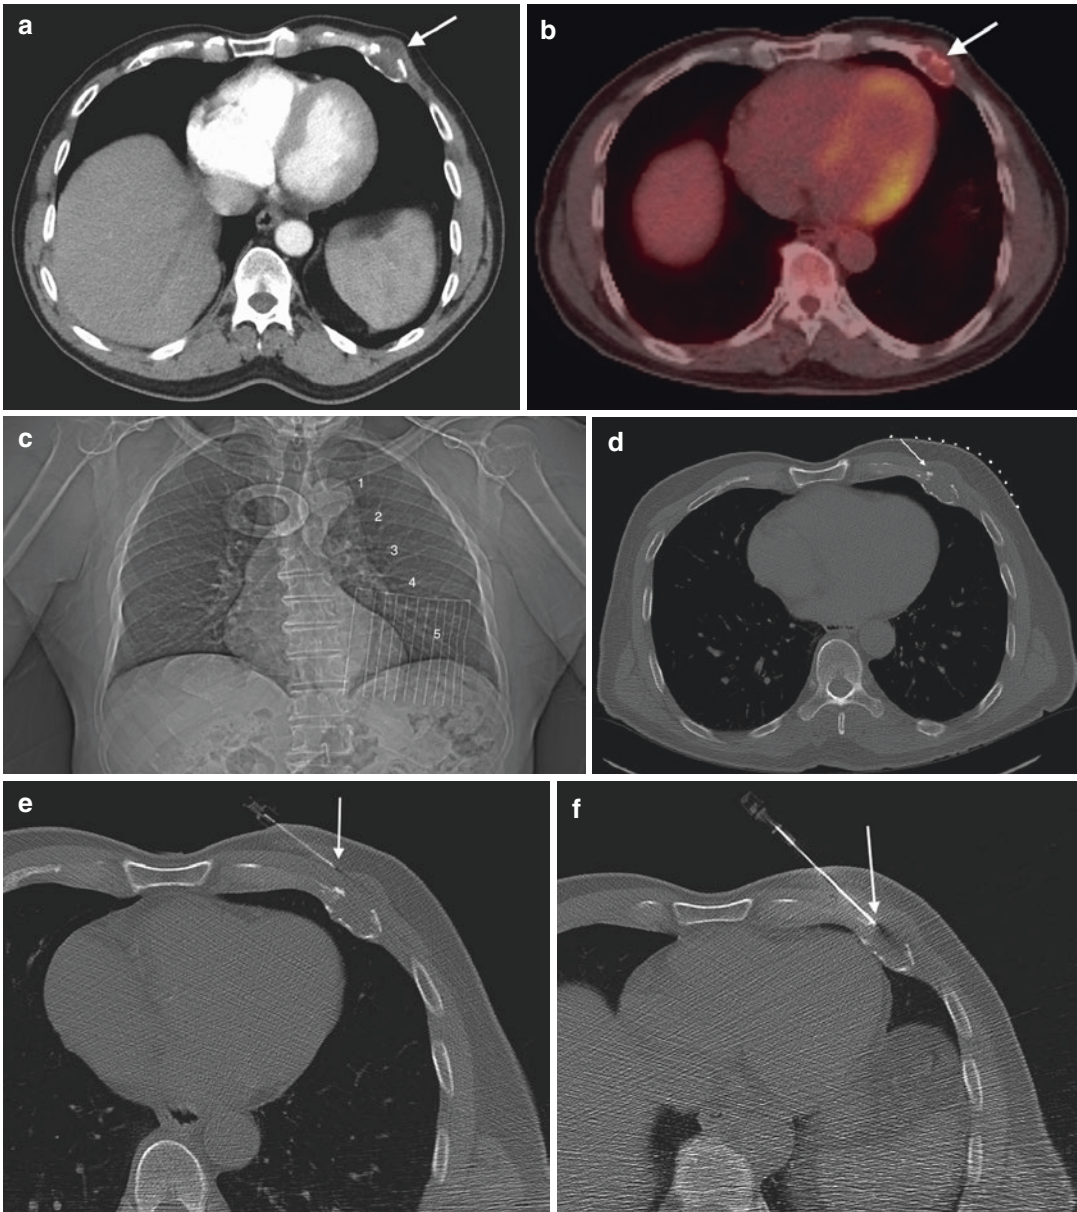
A 70-year-old male with a palpable chest wall mass. Contrast-enhanced axial image (a) from chest CT study shows an expansile left anterior fifth rib lesion with anterior cortical breakthrough and a small extraosseous soft tissue component. Fused axial image (b) from a PET CT study shows avid FDG uptake within the lesion (arrow). Scout frontal CT image (c) with skin grid in place shows the relative location of the left anterior sixth rib (anterior ribs #1 through #5 are numbered). Axial CT image (d) with skin grid in place shows the lateral and downward trajectory (arrow) that can be used with an anterior approach to an anterior rib lesion with the patient in the supine position. Axial CT image (e) shows
